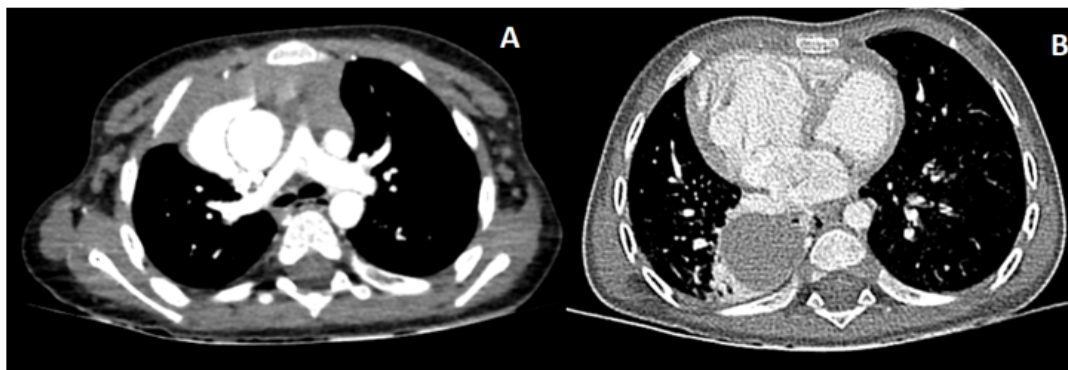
Chest angio-CT axial sections, (A): hypoplasia of the right pulmonary artery, which measured approximately 4.5 mm with hypoplasia of ipsilateral lung; (B): sequestration of the lower lobe of the right lung.
